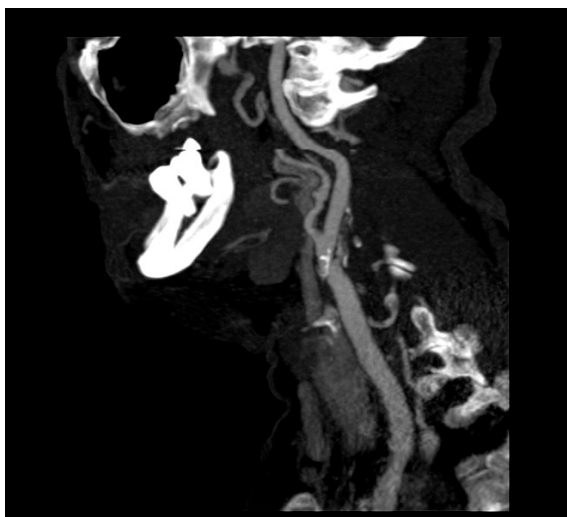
Plaque localization: multislice computed tomographic angiography (MSCTA) finding – a. carotis interna (ACI) prox
